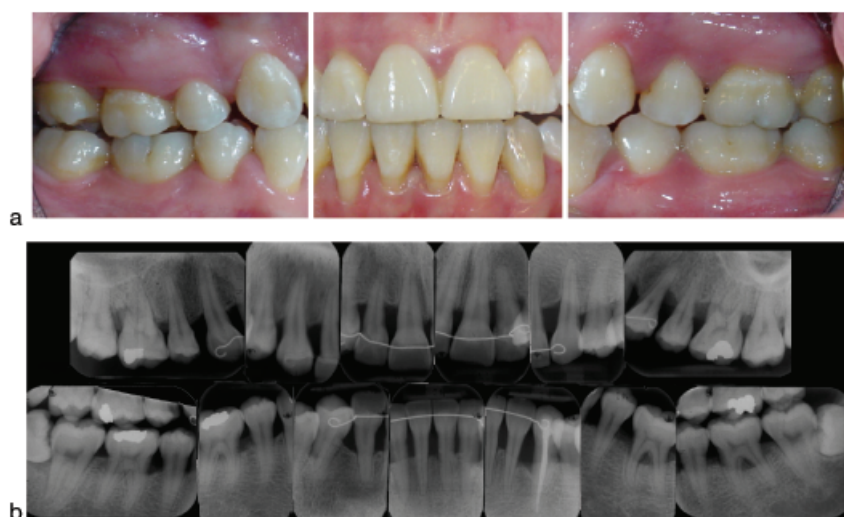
Baseline clinical (a) and radiographic (b) appearance of a 21-year-old, smoking female (eight cigarettes per day). She presented with a plaque score of 24%, a bleeding score of 68% and 70 sites with pockets 5 mm or deeper.
